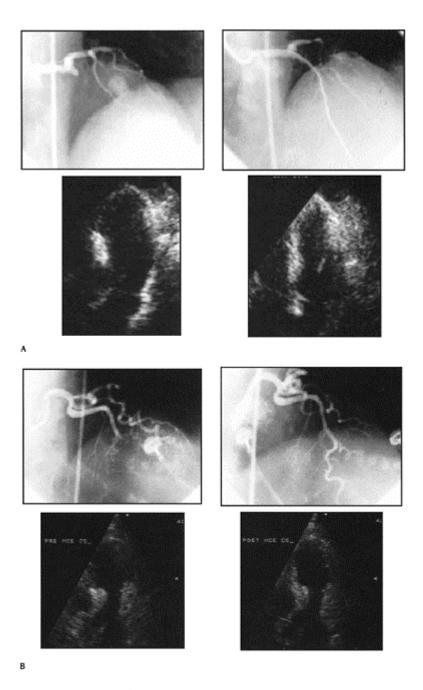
(A) Intracoronary myocardial contrast echocardiography (MCE) before (left), and after (right)
